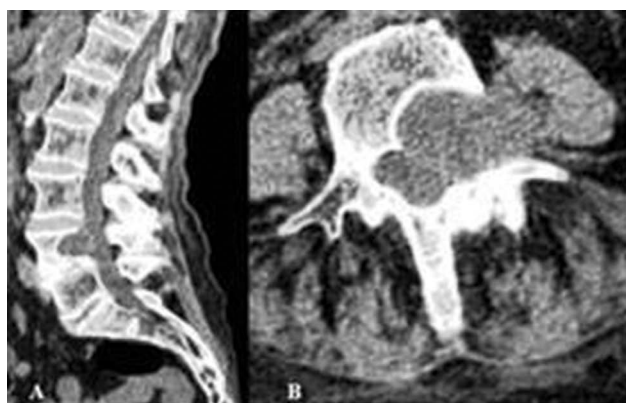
CT of a neurofibroma at the level of L4: A) The sagittal reconstruction visualizes the erosion of the posterior wall of the vertebral body; B) The axial view shows erosion of the pedicle and arch and expansion of the neuroforamen.
